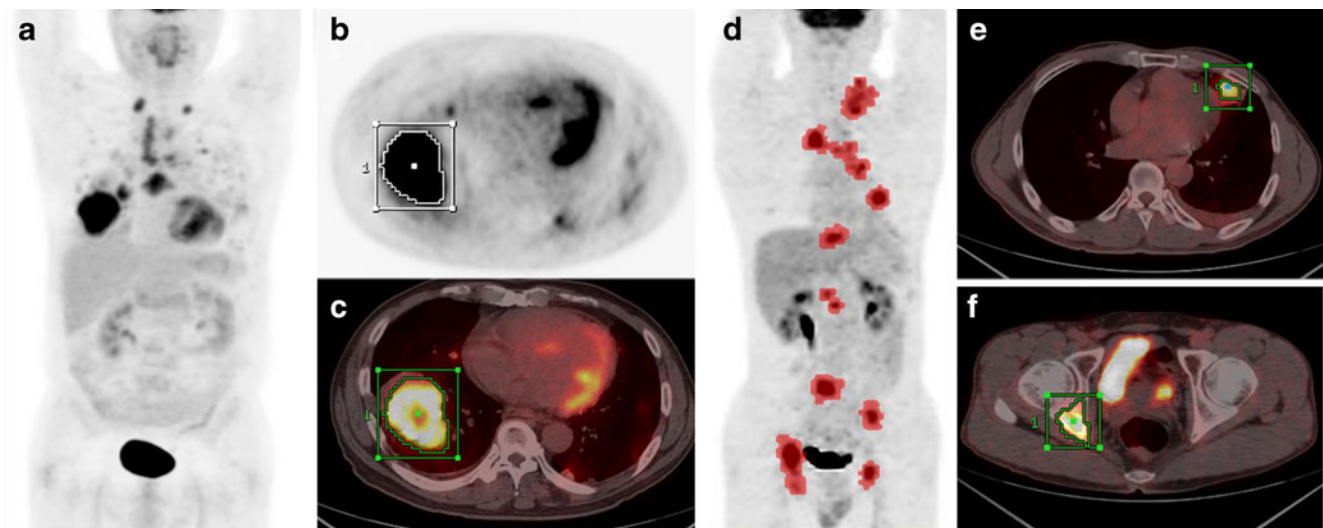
Measurement of metabolic tumor volume (MTV) of primary lung and metastatic tumor lesions in torso using standardized uptake value (SUV)-based automated contouring program. a–c A 64-year-old male patient with multiple lung metastases (M1a). Volume of interest
